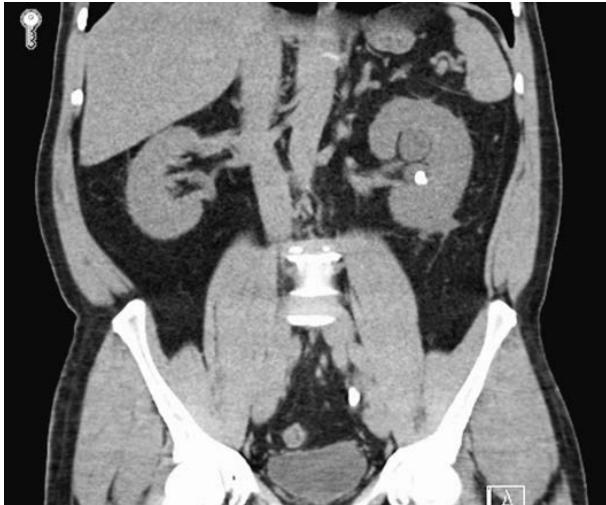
Coronal noncontrast CT image from a patient who presented with left-sided renal colic. An obstructing calculus, present in the distal left ureter at the level of S1, measures 10 mm in maximal dimension. There is severe left hydronephrosis and associated left perinephric fat stranding. In addition, there is a nonobstructing 6-mm left renal calculus in the interpolar region. (Image courtesy of Dr. Stuart Silverman, Brigham and Women's Hospital.)
